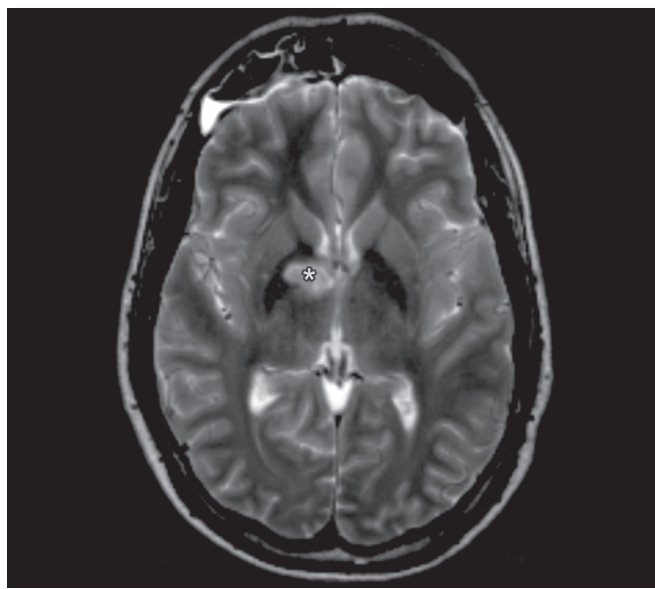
Axial T1-weighted magnetic resonance imaging (MRI) image showing an ischemic thalamic stroke, after perforating arteries injury during a posterior fossa surgery for clivus chordoma.
